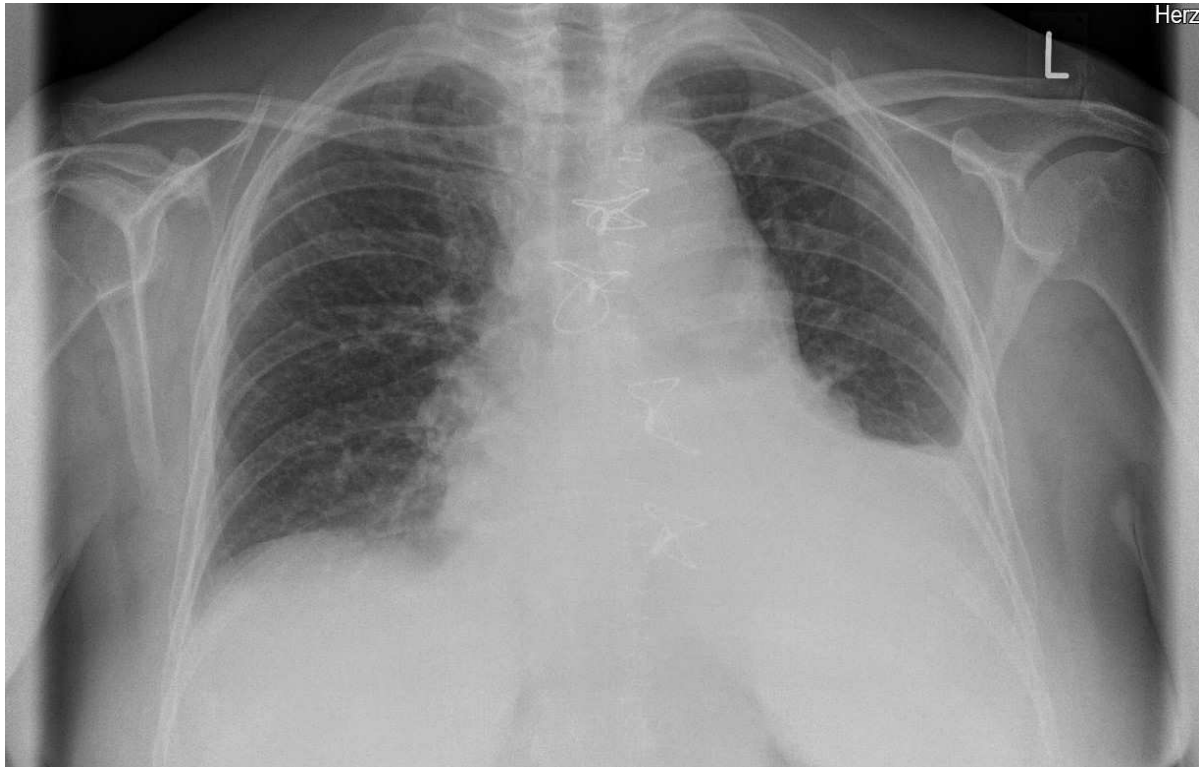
Chest X-ray AP view showing migration of sternal wires due to postoperative sternal instability. (Image Source: Wound clinic, Heart Centre Dresden)
